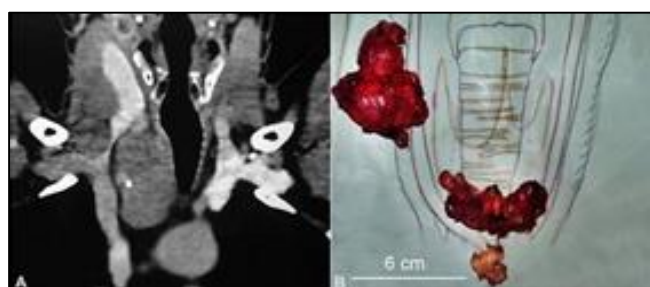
A-CT scan showing paratracheal mass; B - Excision of mass at re-exploration
